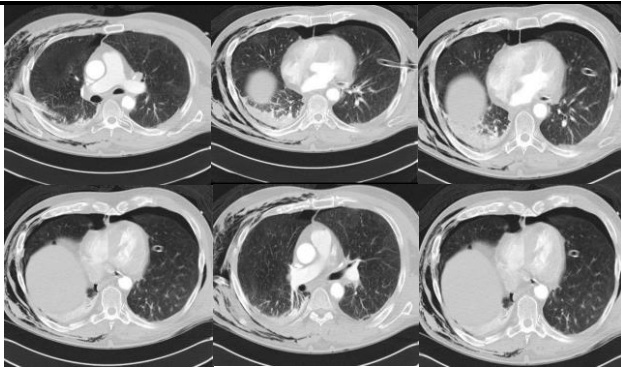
38years old male had RTA with a high-speed motorcycle. CT shows multiple rib fractures from 4th to 10th, with bilateral pneumothorax and bilateral chest tube in the situs extending to the mediastinum. The 4th and 5th ribs are moderately displaced and the 9th rib is fractured anteriorly and posteriorly.
